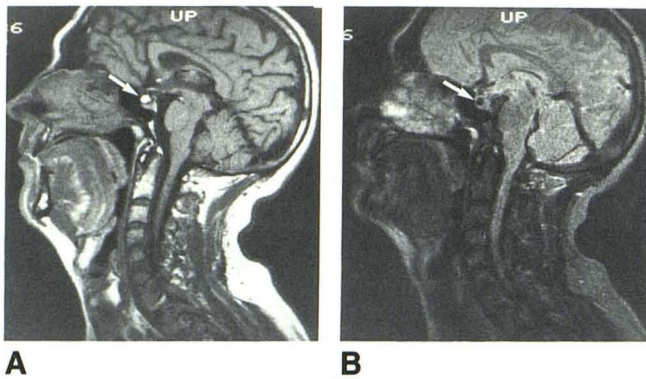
Area of increased signal (arrow) was seen in sella on TR = 500 TE = 30 msec image (A), which is seen as relatively low signal (arrow) on TR = 2500 TE = 80 msec image (B). CT scan showed Pantopaque in sella.
